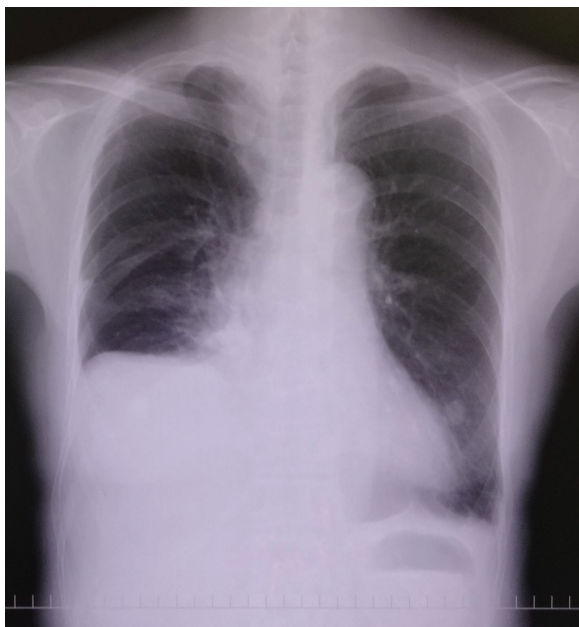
Chest X-ray showing a right-sided hydrothorax due to PPC (Case 4). PPC: pleuroperitoneal communication
